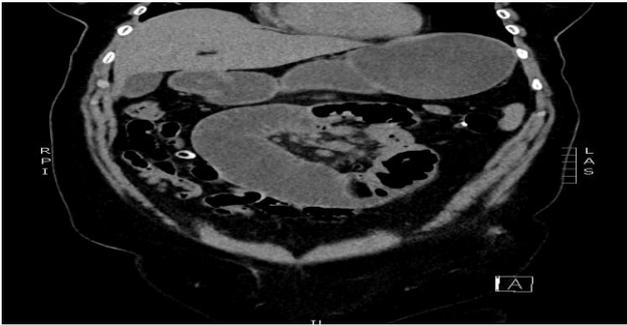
CT image of stricture in small bowel.
